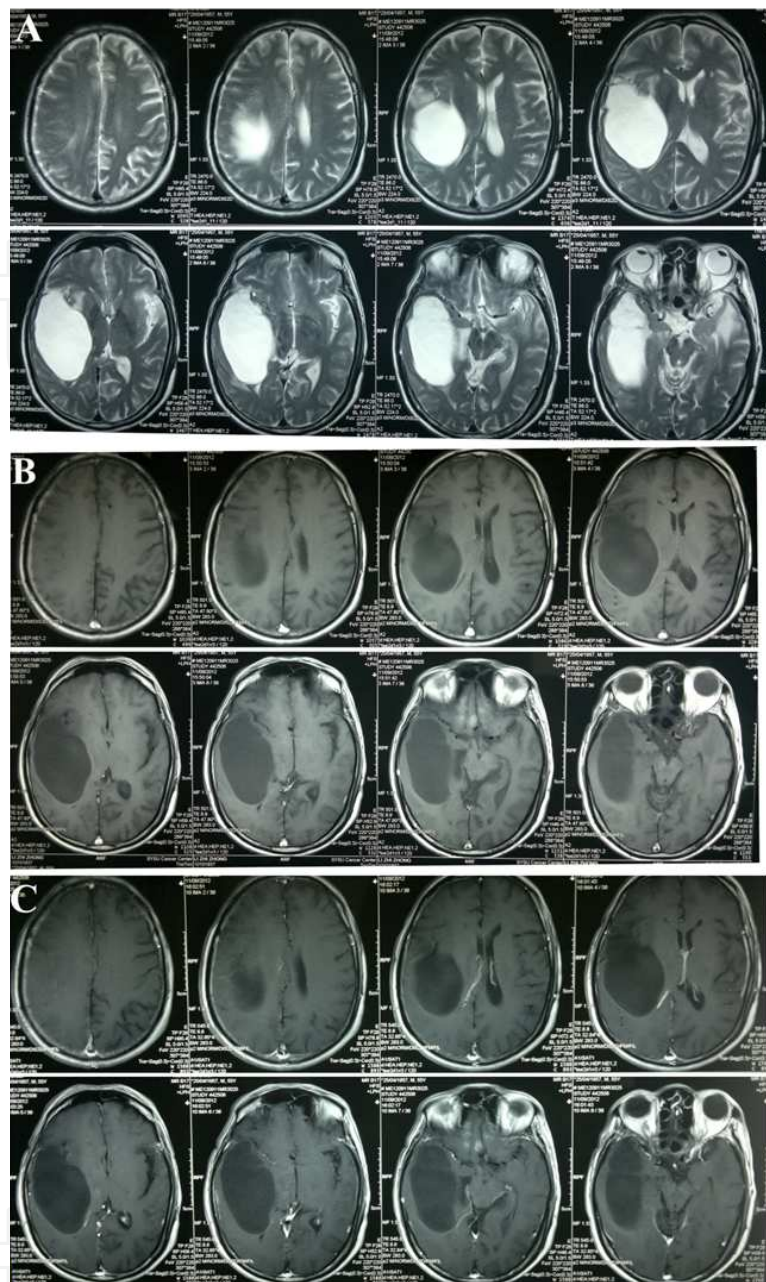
Radiation necrosis and edema. MRI performed 8 years after radiotherapy of one 54-years-old male patient with NPC. Necrosis of right-temporal and right-parietal lobe shows low signal intensity on T1WI and high signal on T2WI with enhanced boundary. Edema of the left-temporal lobe shows finger like low signal intensity on T1WI and high signal on T2WI with non-enhanced boundary. A. T2WI; B. T1WI; C.T1WI+C
